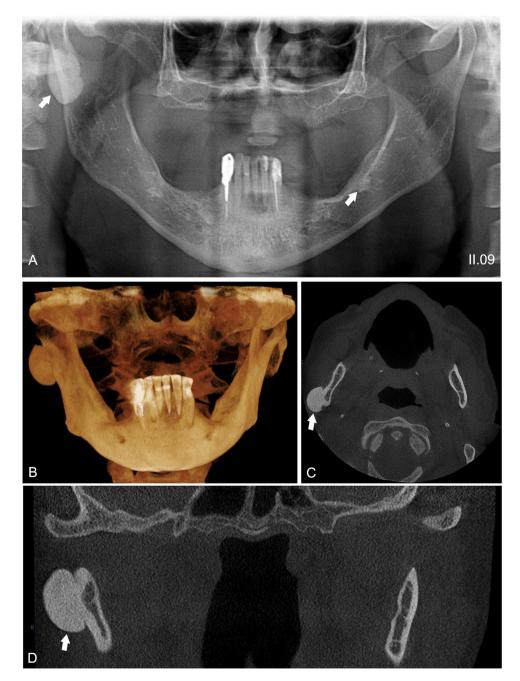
Dento-osseous anomalies found on index patient (white arrows). (A) Patient II.09- Osteoma at the right ramus of the mandible and dense bone island in the body of the mandible on the left side. (B) CBCT 3D reconstruction showing the osteoma. (C, D) CBCT axial and coronal showing the osteoma.
